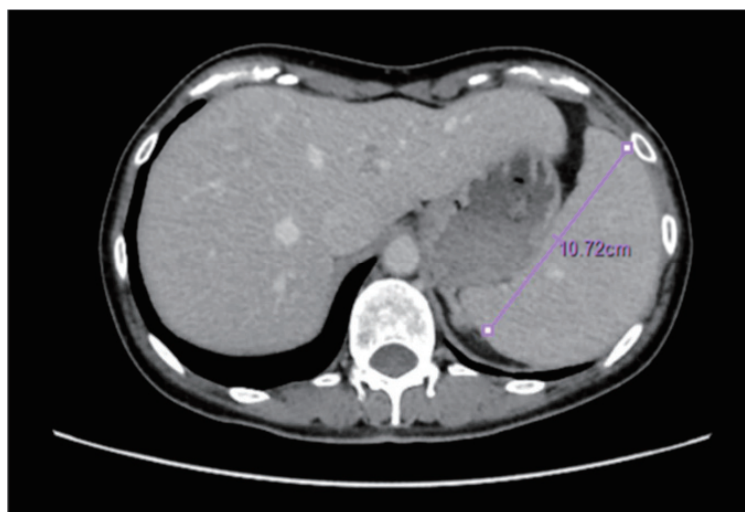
Abdominal CT scan of splenomegaly in female patient with Tangier disease in her 40s
